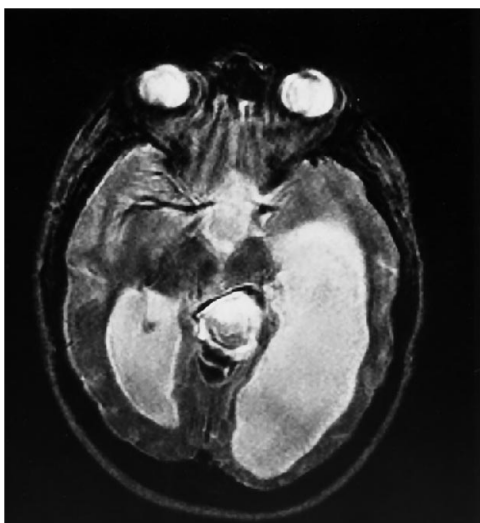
Axial spin-echo MR image (2450/100/2) 10 months after treatment shows hyperintensity within the shrunken median vein of the prosencephalon, with peripheral hypointensity of calcium and/or hemosiderin. MR angiography showed no arterial flow to the median vein of the prosencephalon.
